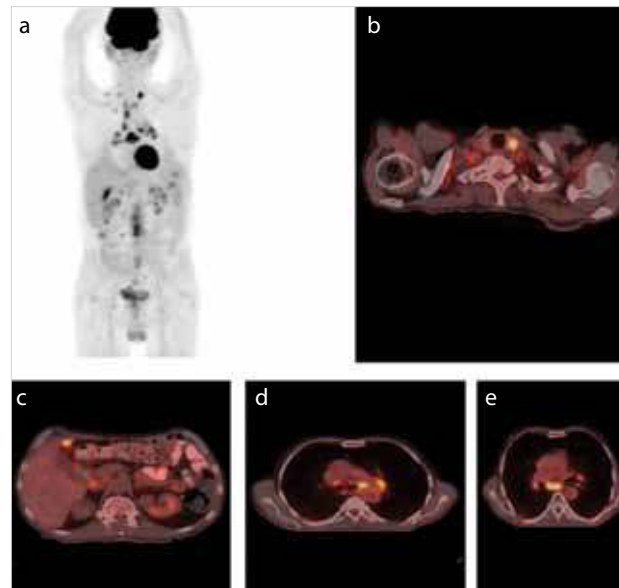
PET/CT for re-staging; 6 years old male, colon cancer a) Total body PET view b) Slightly increased FDG uptake in the neck adjacent to the left thyroid lobe c) Subcapsular metastatic foci in Segment 2 and 10x9 mm lymph node in the right para-caval region d) Left paraoesophageal and aortopulmonary lymph nodes e) 14x9 mm lymph node right lateral to the ascending aorta
